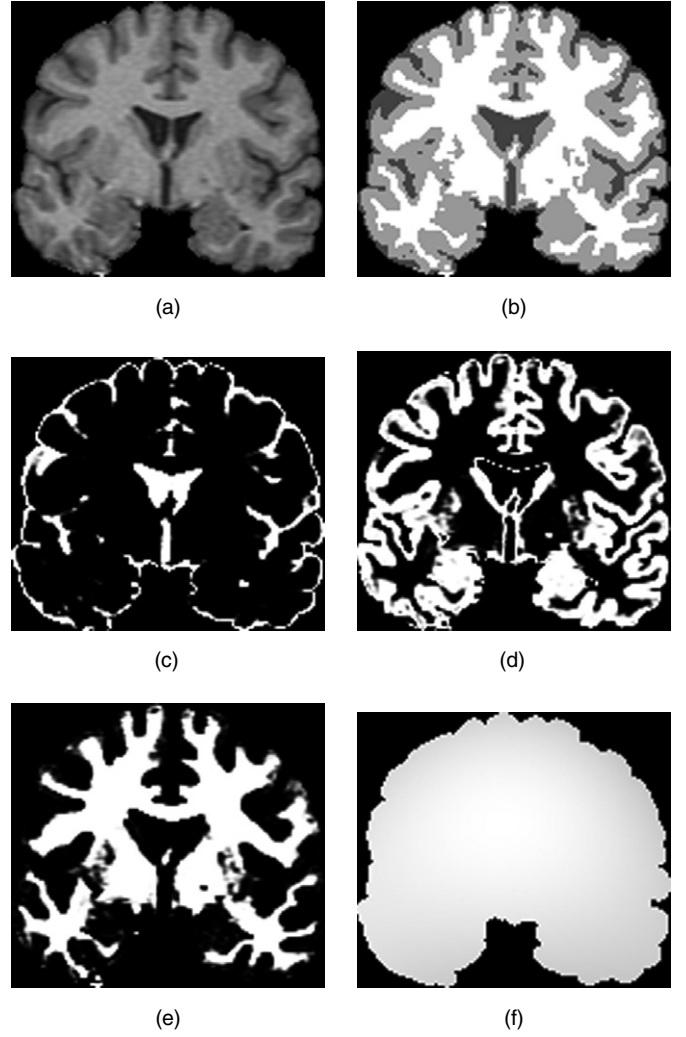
Robust EM algorithm example: (a) T1-weighted MR image, (b) final classification, (c) CSF posterior probability function, (d) GM posterior probability function, (e) WM posterior probability function, (f) estimated inhomogeneity field.
